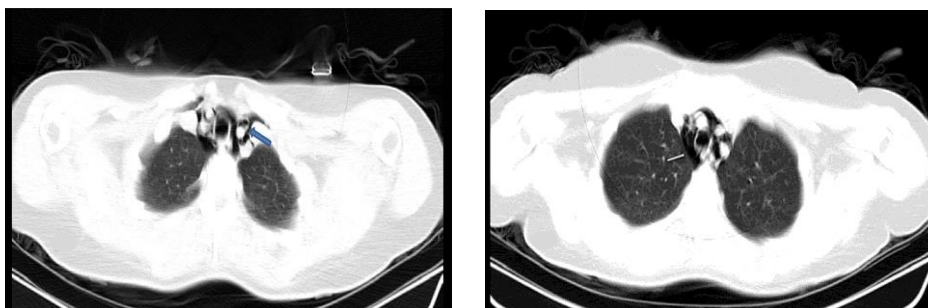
CT imaging shows the air in mediastinal space (arrow)
